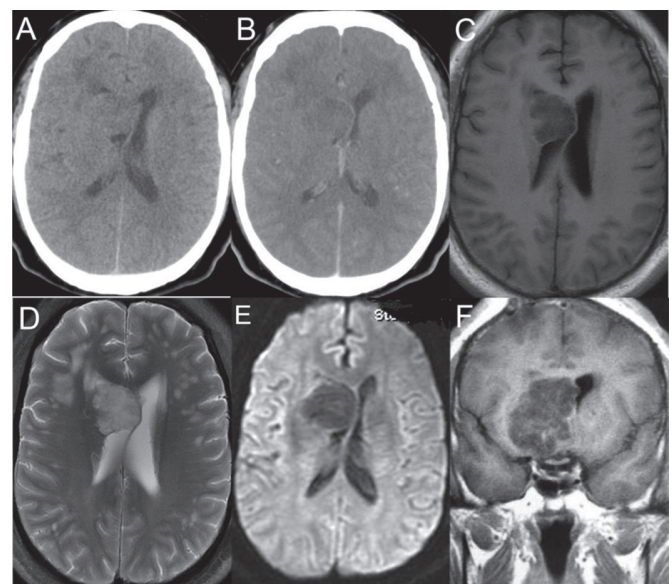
Axial CT scan (A, B) at the time of admission and MRI sequences (C–F) show a defined paraventricular cryptococcoma involving the right basal ganglia
